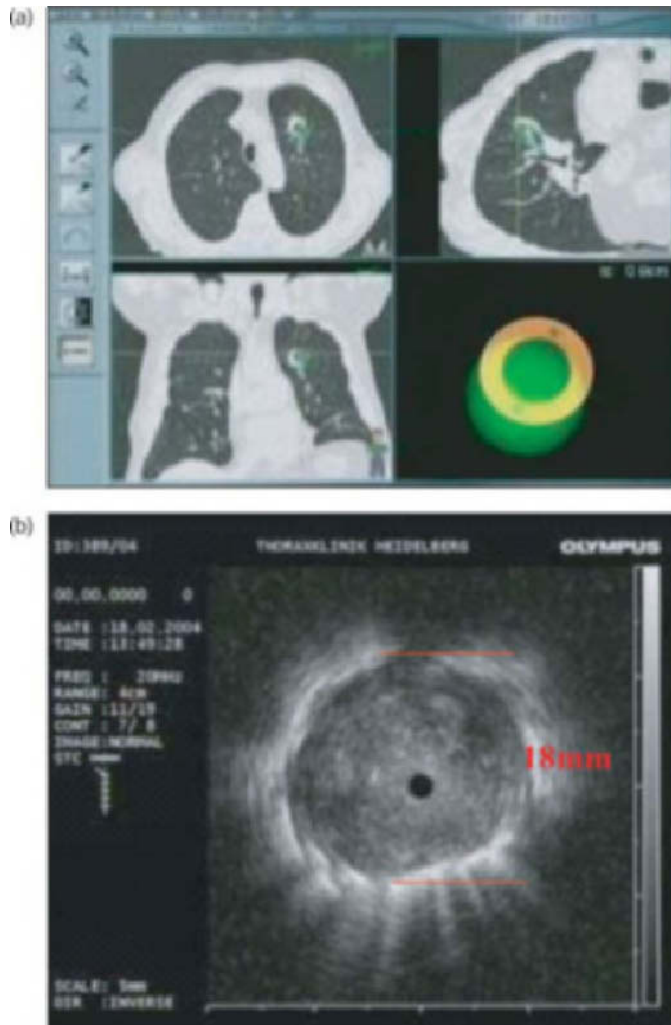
A sensor is navigated into an 18-mm peripheral lesion in the apical segment of the left upper lobe (a). The exact central position of the catheter and the size of the lesion is confirmed by introducing the endobronchial ultrasound probe (b).
